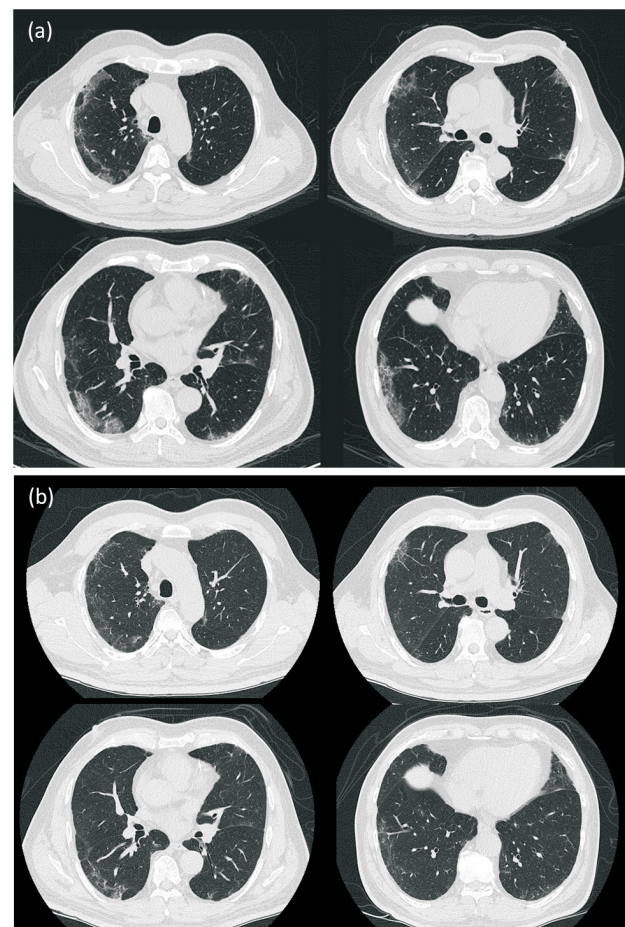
(a) Chest CT on hospital day 3 showed bilateral subpleural GGO involving predominantly the upper and middle lung. (b) Chest CT four days after discharge showed bilateral improvements in GGO. CT: computed tomography; GGO: ground glass opacity.
